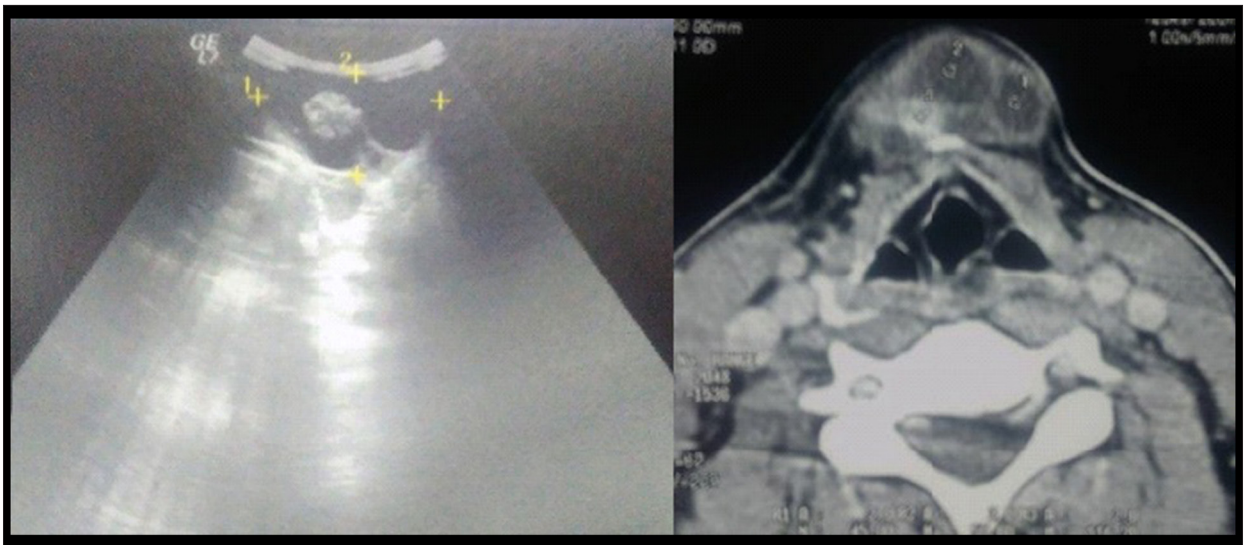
Ultrasound and computed tomography (CT) imaging of the neck confirmed a 6 cm diameter multilocular, midline, thyroglossal duct cyst.
